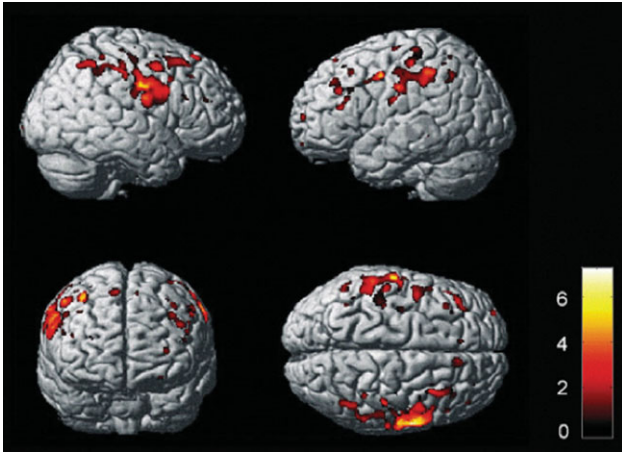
GM atrophy (in red-yellow on a standard T1-weighted brain) in patients with ALS compared with healthy subjects is evident bilaterally not only in the primary motor cortex but also in the premotor, parietal and frontal regions. Reprinted with permission of BioMed Central: BMC Neurol 2006;6:17.
